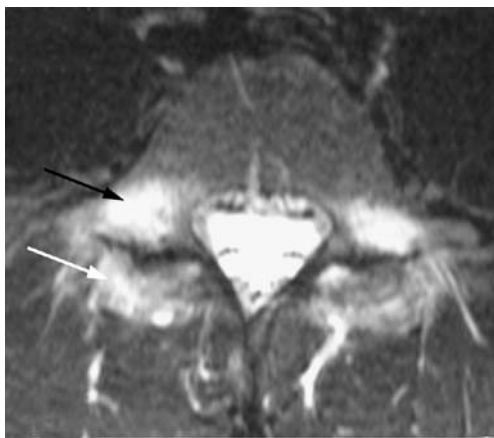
Muscle edema in a 14-year-old patient with acute spondylolysis. Muscle edema (*white arrow*) and bone edema (*black arrow*) are shown as areas of high signal intensity on axial T2-weighted MR image [time to repeat (TR) 5200 ms; time to echo (TE) 80 ms]
